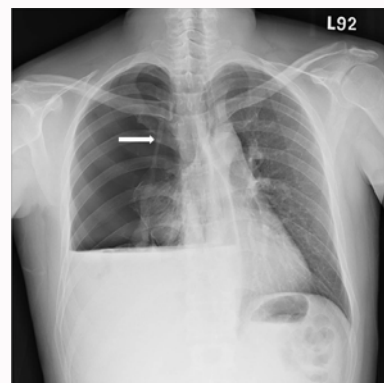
A chest-X-ray showed a right pneumothorax with a moderate amount of pleural effusion. Of note, a collapsed lung with a visible adhesion band connecting to the apex of chest is clearly demonstrated.
